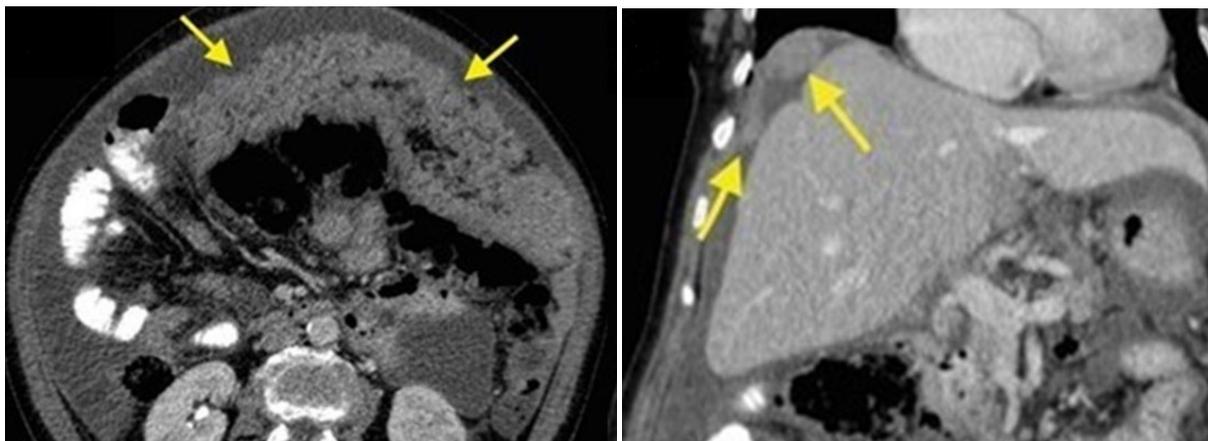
Peritoneal carcinomatosis secondary to ovarian serous cystadenocarcinoma. (A) Axial IV and PO contrast-enhanced CT scan shows omental cake appearance (arrows). (B) Coronal reformatted contrast-enhanced CT scan demonstrates two peritoneal implants in the right subphrenic space.
